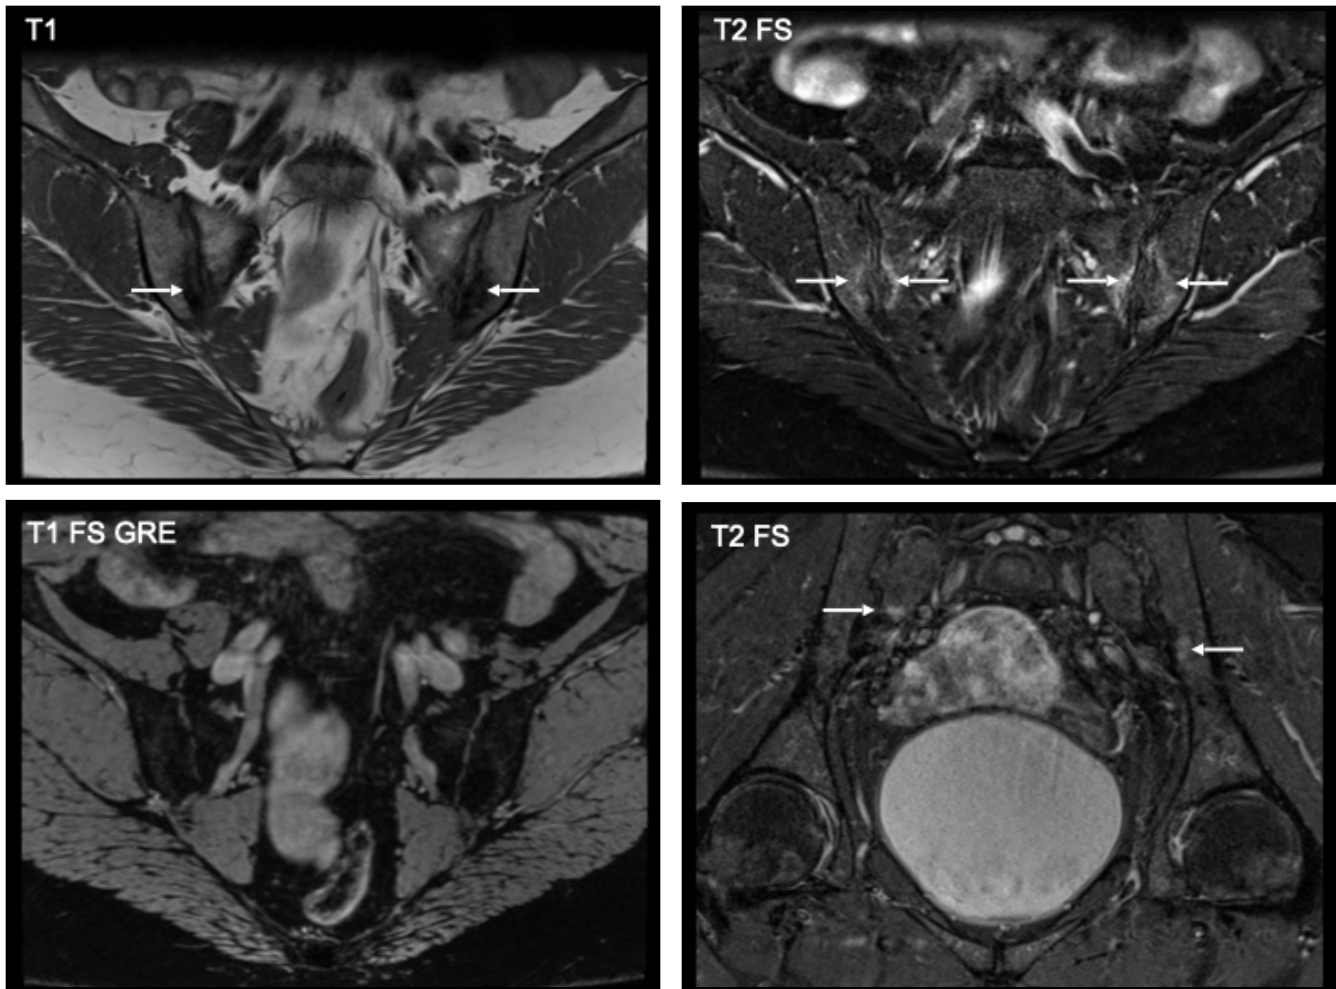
Typical patterns of MRI changes in the sacroiliac joints in osteitis condensans; *courtesy of Denis Poddubnyy, MD, PhD, MSc (Epi).*
